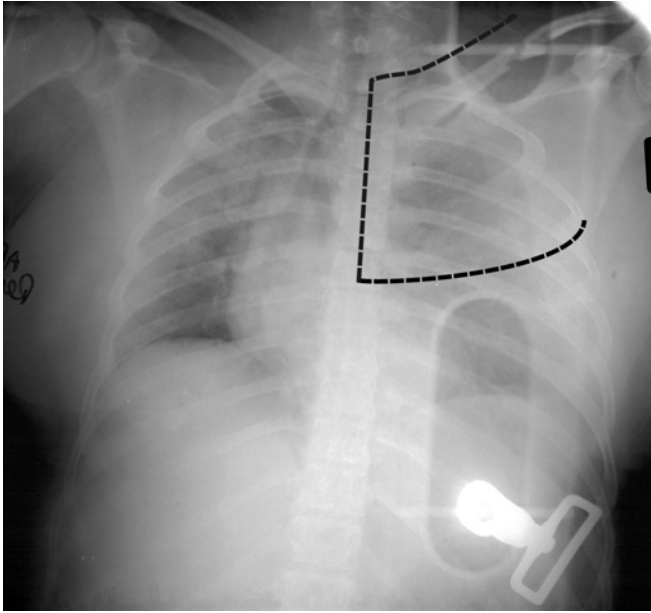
Chest x-ray of the patient demonstrates clavicle fracture and fractures of the first and second ribs. Dashed line indicates surgical incision.
